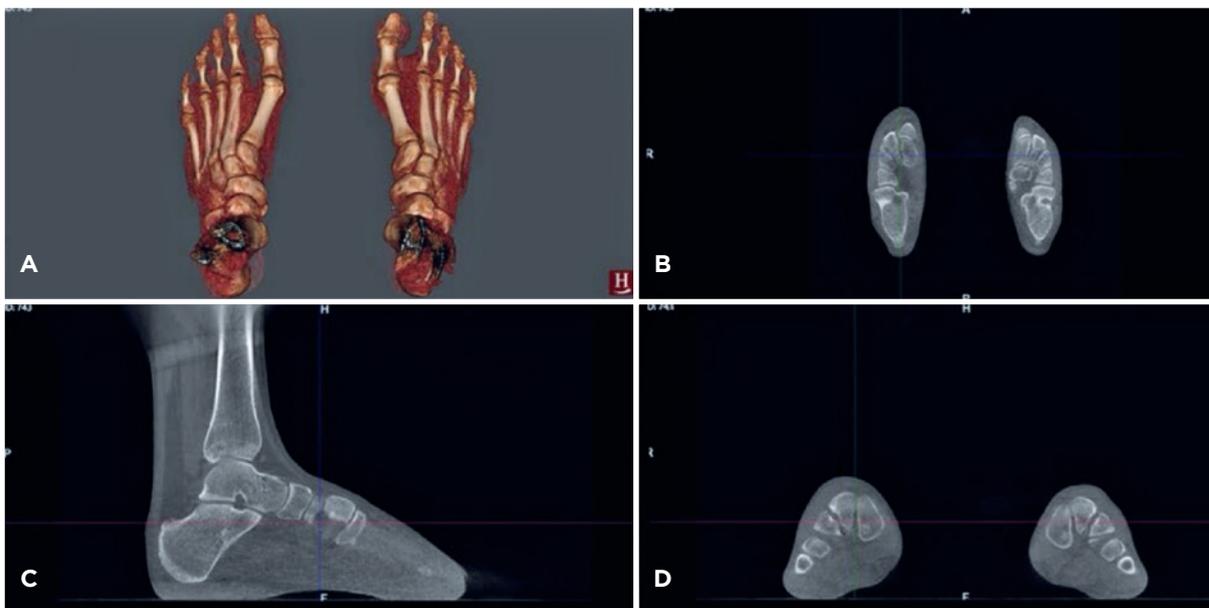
Normal weight-bearing computed tomography. A) 3- dimensional image of the bones; B) Axial image; C) Sagittal image; D) Coronal image.
